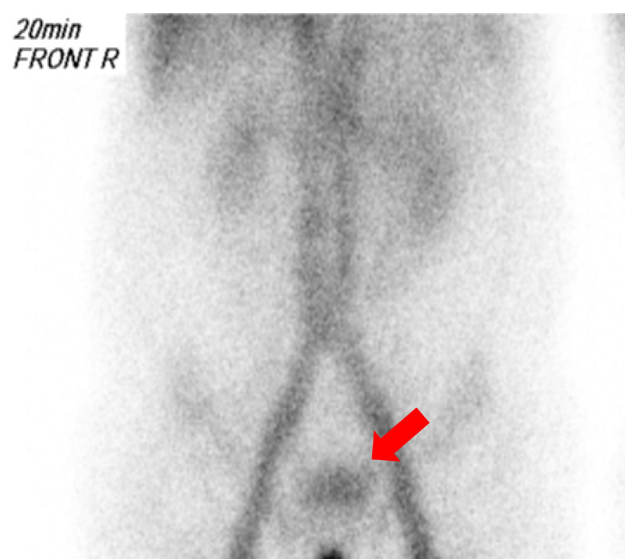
Gastrointestinal bleeding scintigraphy revealed accumulation of nuclide around pelvic lesions in the early phase at 24 hours (arrow).
